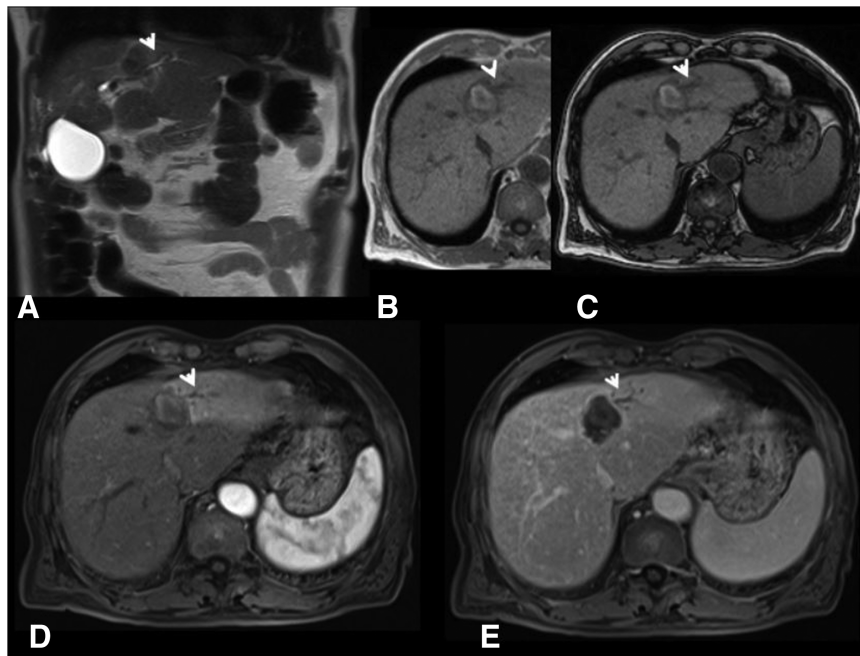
A 72-year-old woman with peribiliary colorectal liver metastasis treated with microwave ablation. Magnetic resonance imaging [(A) half-Fourier acquired single-shot turbo spineEcho T2 weighted coronal plane; (B) T1-W in of phase in axial plane; (C) T1-W out of phase in axial plane; (D) volume-interpolated breath-hold examination T1 weighed fat sat during arterial phase of contrast study; (E) VIBE T1-W FS during portal phase of contrast study] study shows the lesion with hypointense signal on T2-W, hypointense signal on T1-W (B and C), without contrast enhancement (D and E) and with biliary injury (dilation of a biliary branch; arrows).
